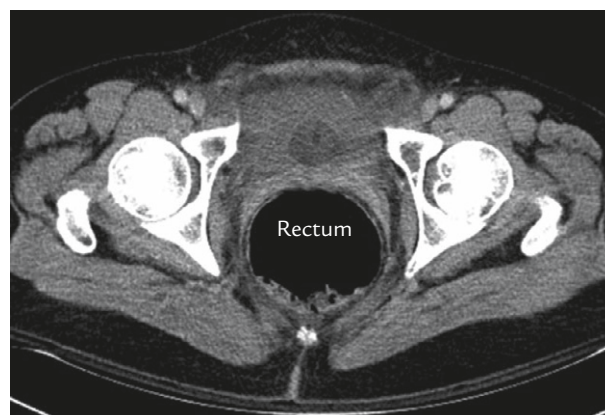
Computed tomography shows a dilated rectum filled with air but with no flatus passage in a patient with postoperative ileus due to pelvic abscess caused by inadvertent injury of the sigmoid colon.
